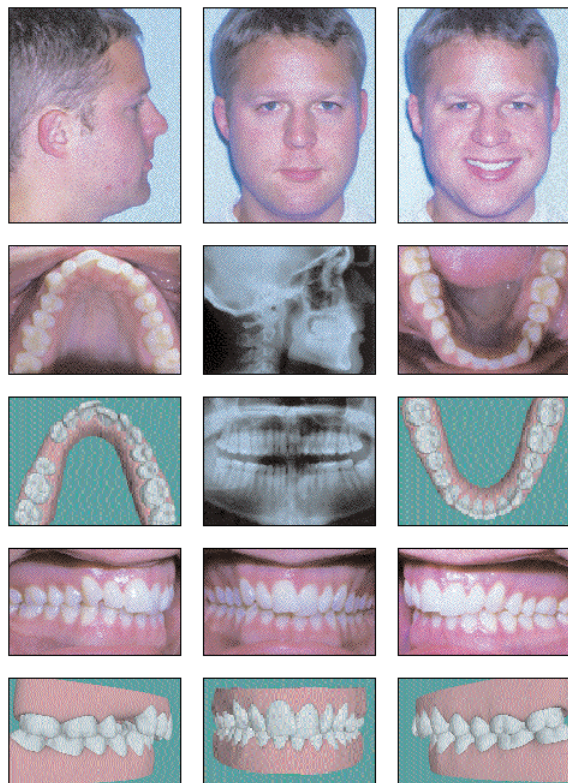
The pre-treatment images of this patient reveal moderate crowding, midline deviation, deep bite, and a unilateral Class II subdivision (right) malocclusion. Findings from the cephalometric and panoramic radiographs are non-contributory. Maxillary right first premolar was extracted to finish with a Class II molar relationship on the right and Class I on the left.
